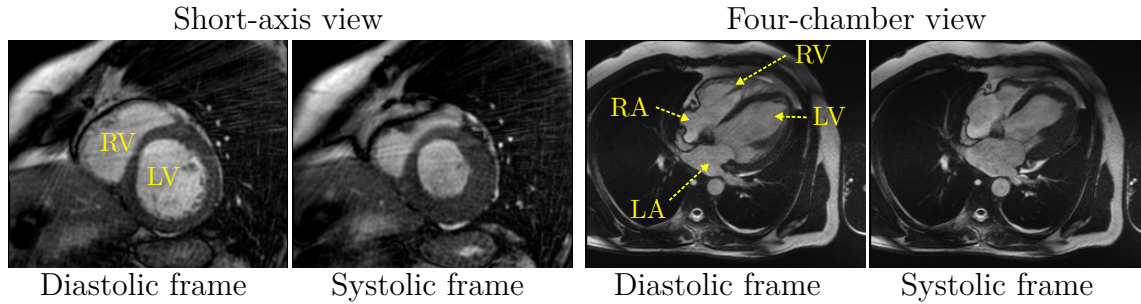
Example SSFP cardiac cine MRI: one diastolic (maximum ventricular blood volume) and one systolic (contracted heart, minimum blood volume) frame among typically 25–30 frames are visualized. Images courtesy of Siemens Healthineers.
